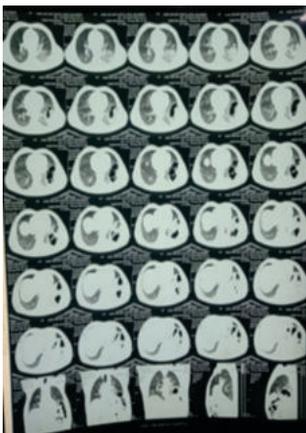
showing HRCT Thorax, which reveals traumatic diaphragmatic herniation on left side with multiple rib fracture from 8th to 11th.
